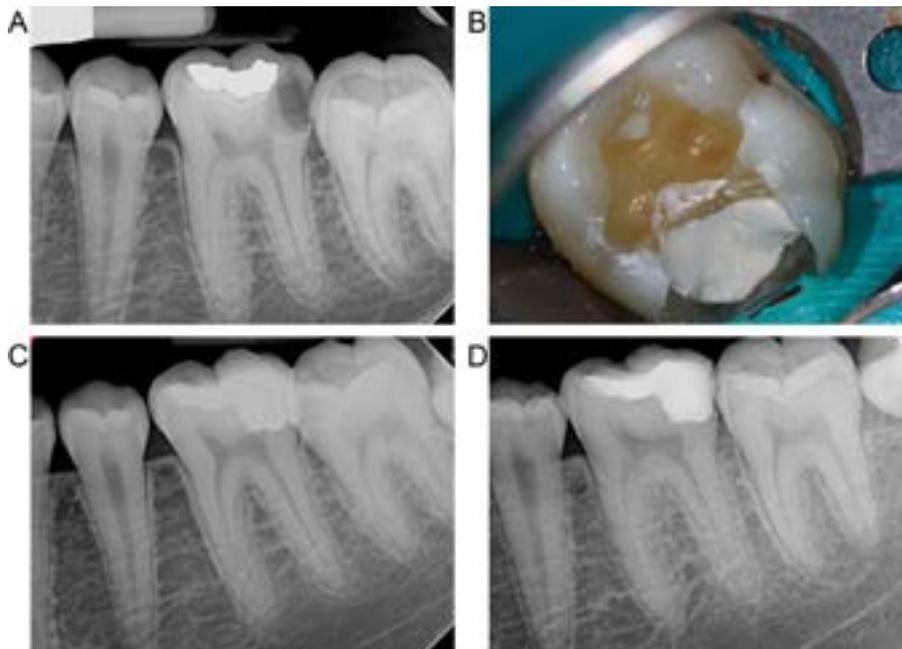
(A) Preoperative radiograph of carious exposure on tooth 36. (B) Direct pulp coverage with BC Sealer. (C) Immediate postoperative radiograph. (D) Radiograph taken at 6-month follow-up visit. Courtesy of Dr. Mohammed A. Alharbi.
